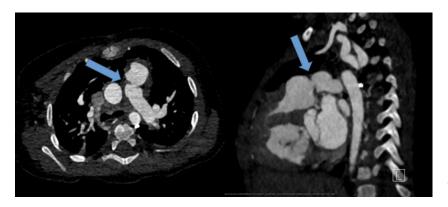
Axial and sagittal view from computed tomography angiography for patient 1 obtained 5 months after BA of IPAB demonstrating a patent fenestration (blue arrows) measuring 4.8 mm. BA = balloon angioplasty; IPAB = internal or intraluminal pulmonary artery banding.
